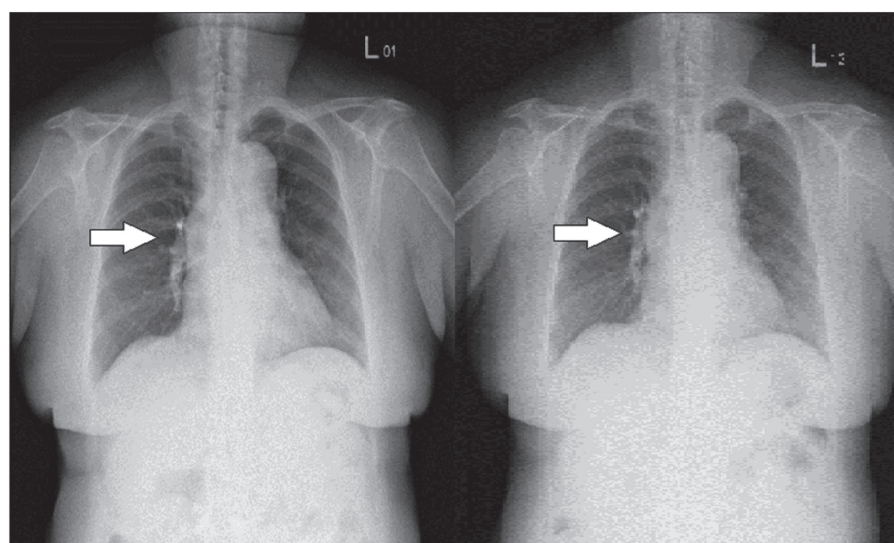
The chest x-ray (CXR) images show posterioranterior view of reduced amount of cement emboli five and 23 months after discharge, respectively.
